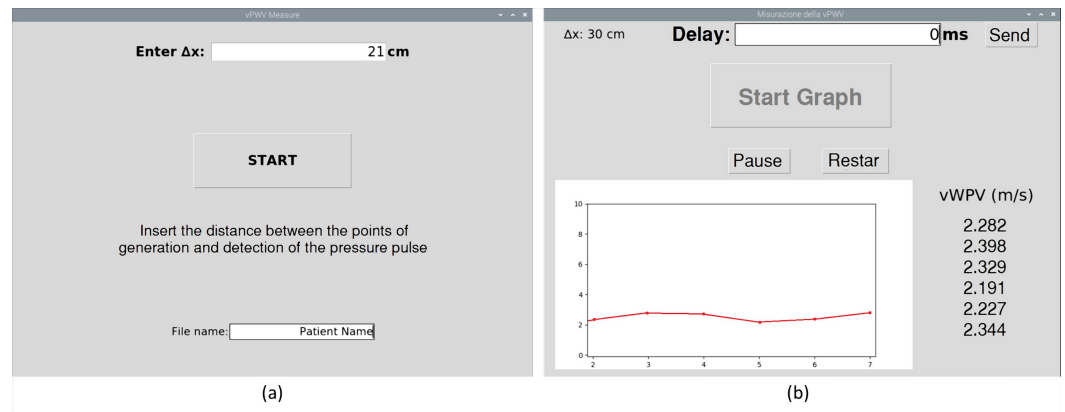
Graphical user interface. (a) GUI's first page allows to enter the preliminary information, such as the distance between the cuff and the ultrasound probe (Δx), and the name for saving the data. (b) In working mode, the GUI displays numerical and graphical representation of measured vPWV values, and allows to adjust the additional delay for the delivery of the compressive stimulus.
